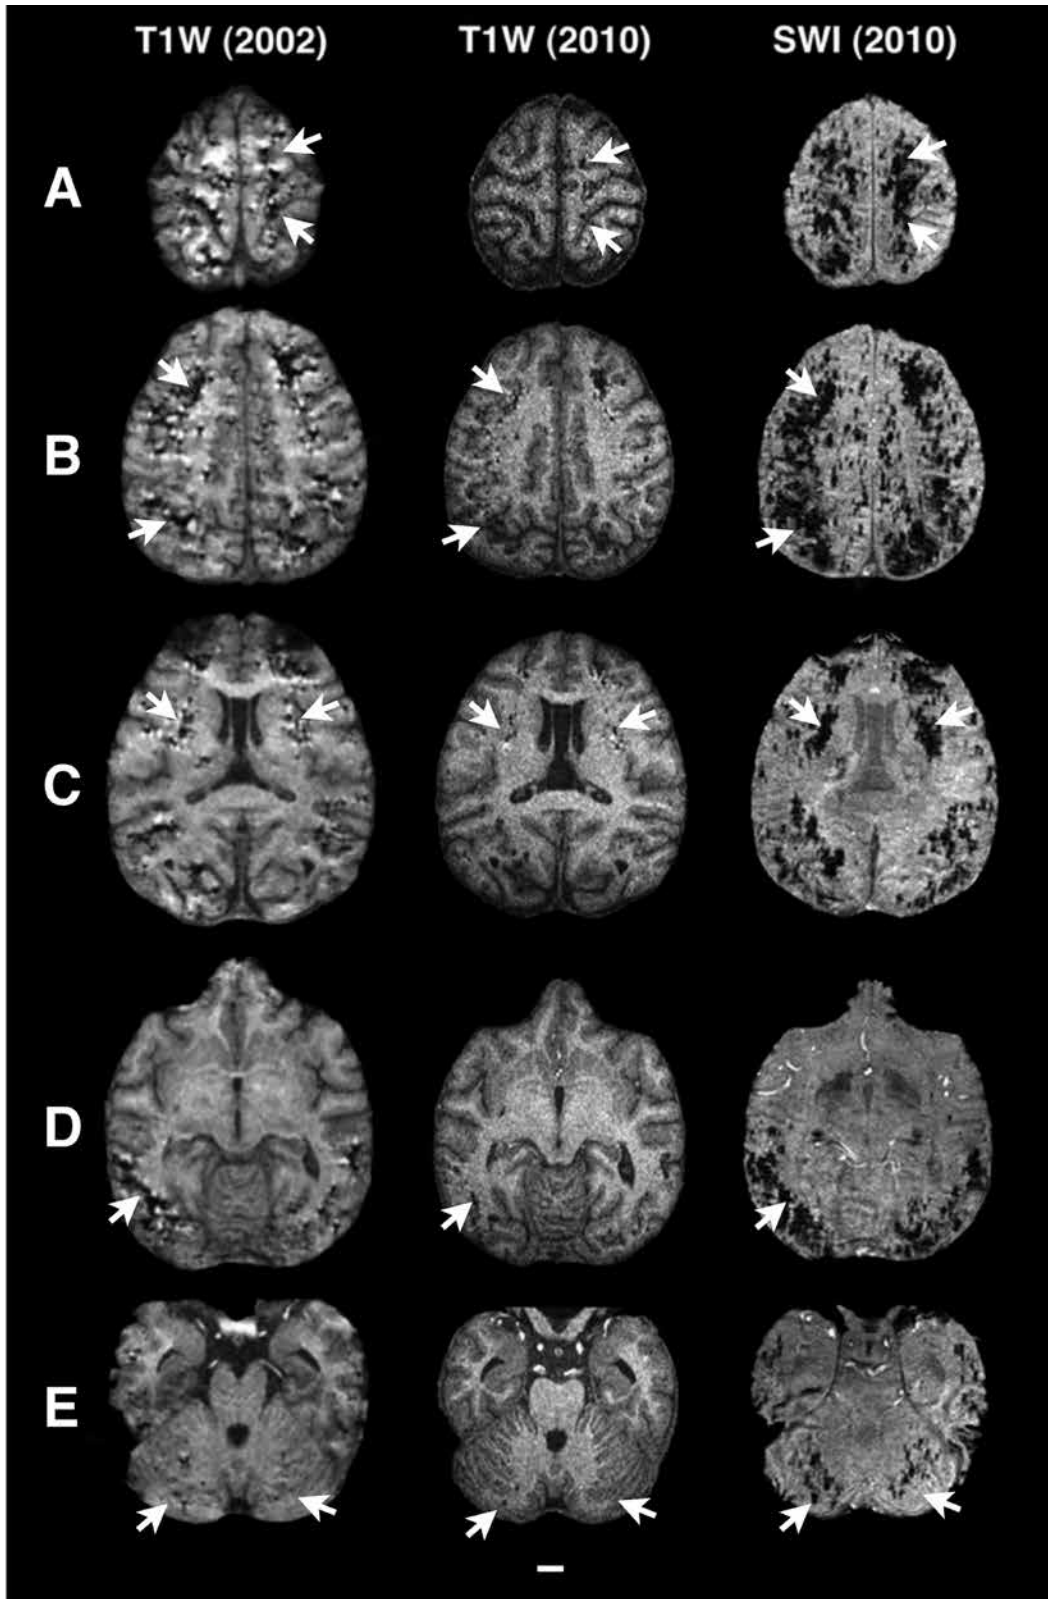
Series of axial MRI scans, including T1-weighted images taken in 2002 and T1- and susceptibility-weighted images taken in 2010, showing large territories of abnormal signal that appear dark in both T1- and susceptibility-weighted imaging. At each level, arrowheads denote the location of abnormalities in matched locations from the 2002 and 2010 T1-weighted and 2010 susceptibility-weighted scans. The abnormalities denoted with arrowheads are located in (A, B, D) the gray and white matter of the cerebral cortex, (C) the basal ganglia, and (E) the cerebellum. In the T1-weighted scans, the abnormal, dark territories appear to be larger in 2002 than in 2010. The susceptibility-weighted scans from 2010, however, show larger abnormalities than those in either of the T1-weighted series. Scale, 1 cm.
